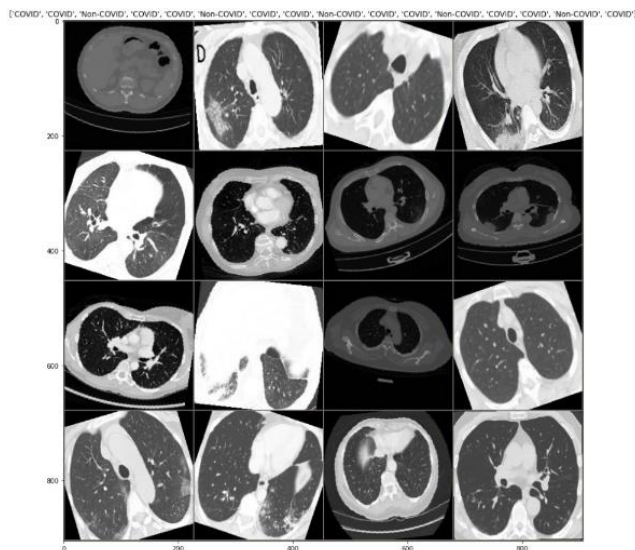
Chest CT images after preprocessing*
